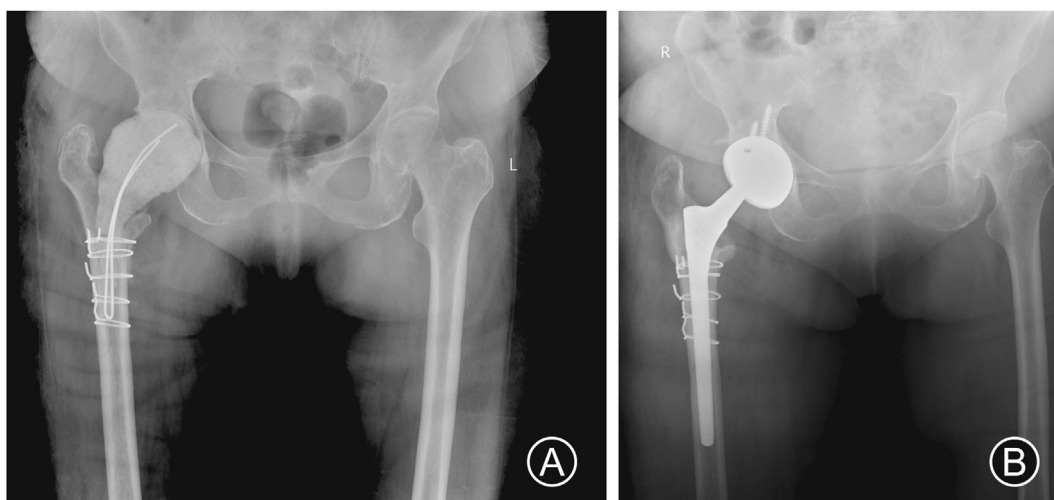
(A) Postoperative AP X-ray shows an antibiotic-loaded, articulating hip spacer in situ after the third debridement for periprosthetic joint infection. (B) The revision was performed using a cementless femoral stem and a porous tantalum acetabular cup.
